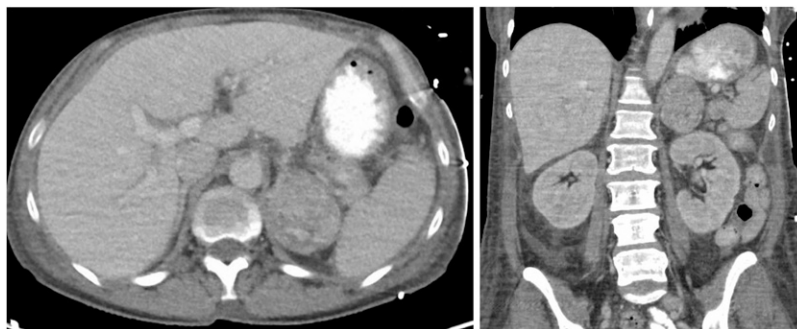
CT scan images: axial and coronal views of the left adrenal tumor.
